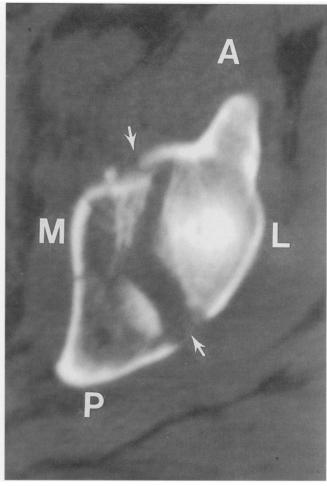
Note the classic anterior to posterior fracture pattern on the CT cut through the dome (white arrows), indicating a transverse fracture rather than column fracture.
